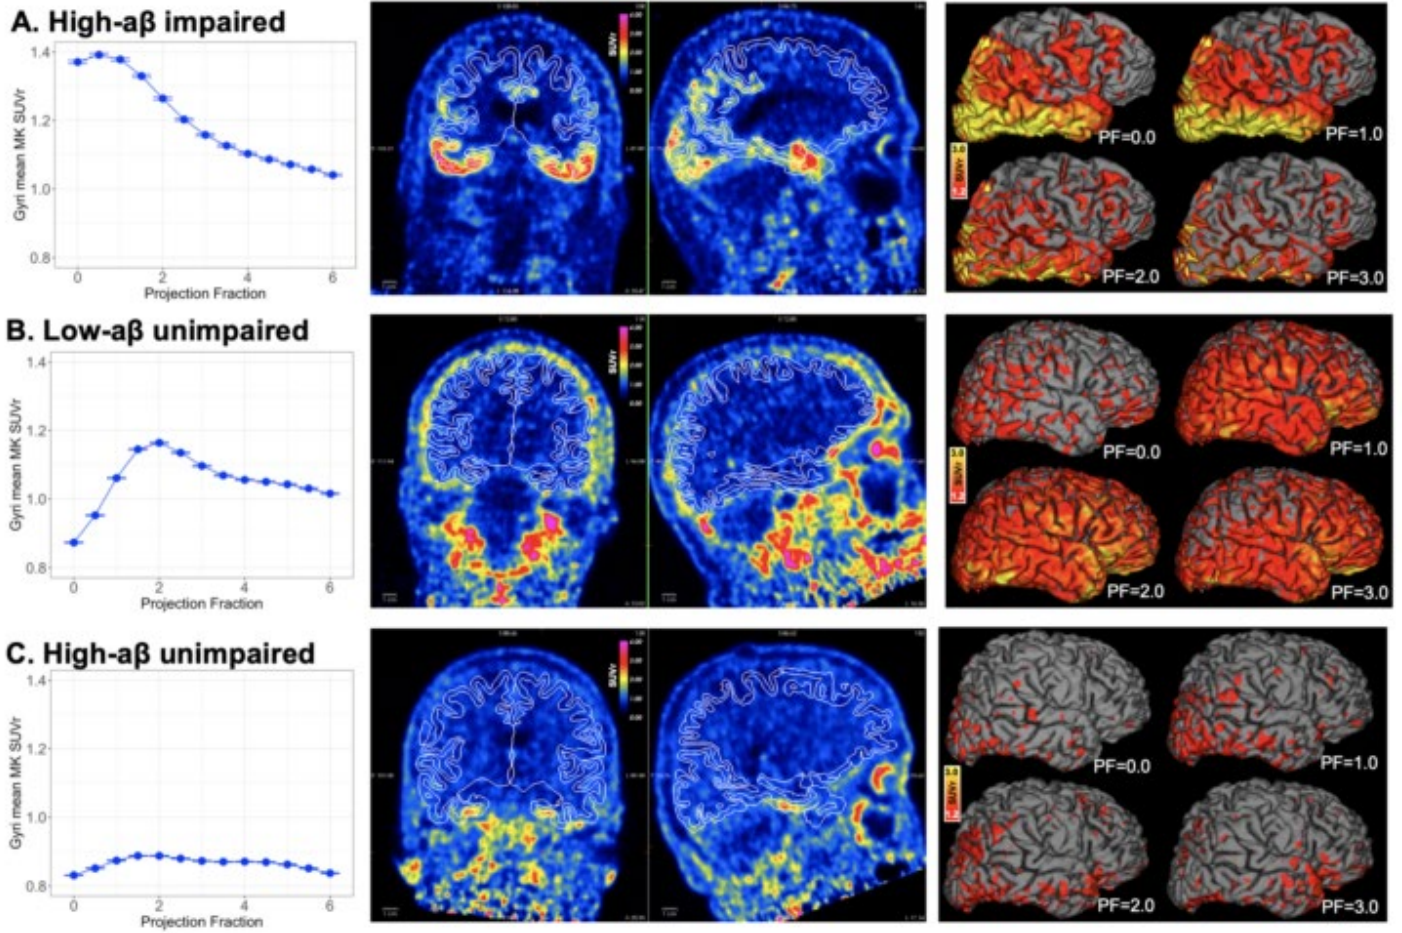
Three example cases showing (left to right) the change in mean MK6240 SUVr with change in projection fraction (PF), coronal and sagittal slices of MK6240 signal in relation to pial surface, and vertex-wise whole brain SUVr at various PF values. A) Impaired 59 year old male with high amyloid (Global PiB DVR=1.58); B) Cognitively normal 44 year old male with low amyloid (Global PiB DVR = 1.01); C) Cognitively normal 66 year old female with high amyloid (Global PiB DVR = 1.53)
